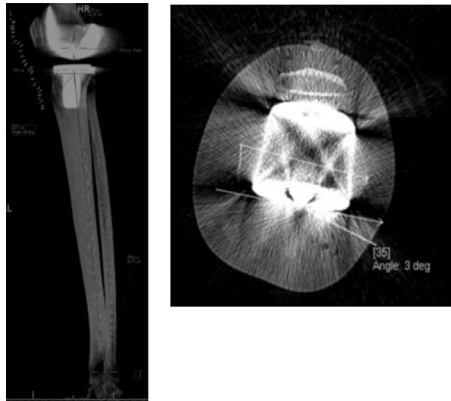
CT Perth Protocol measurements of tibial component slope and femoral component rotation.
